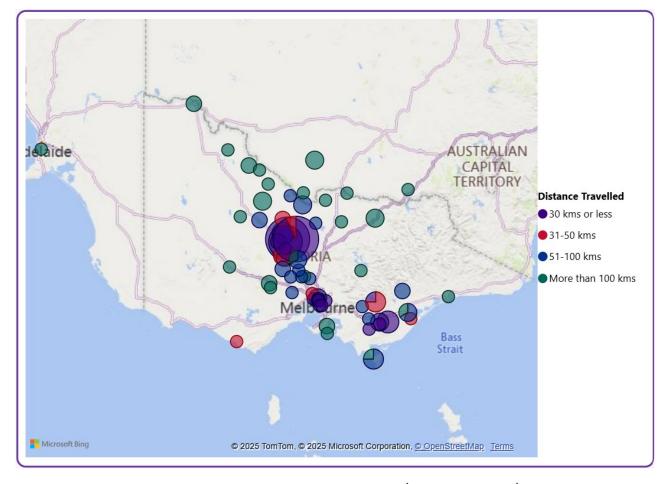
Geographic distribution of CT participants at TrialHub flagship sites
